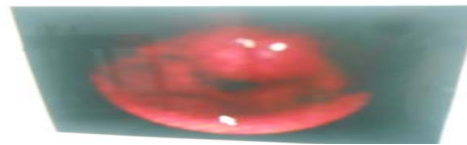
Laryngoscopic view of the submucosal growth over the interarytenoid region. Computed tomography (CT) demonstrated a 22 × 23 × 28 mm well defined, round to oval, mass arising posterior pharyngeal wall growing under intact mucosa. Compared to muscle it was hypodense, slightly inhomogeneous with a clear capsule and no sign of infiltrative growth or cartilaginous destruction (Figure 2).
